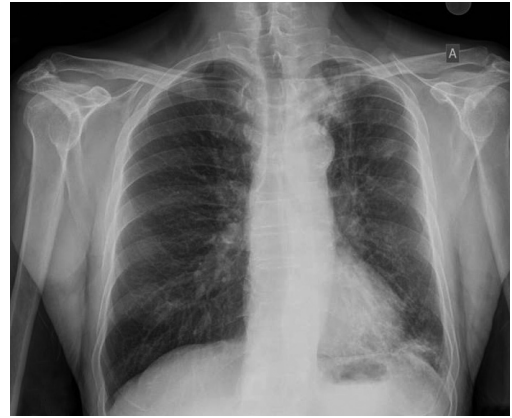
Repeat chest radiograph showing a decrease of the infiltrates and total left lung expansion.
